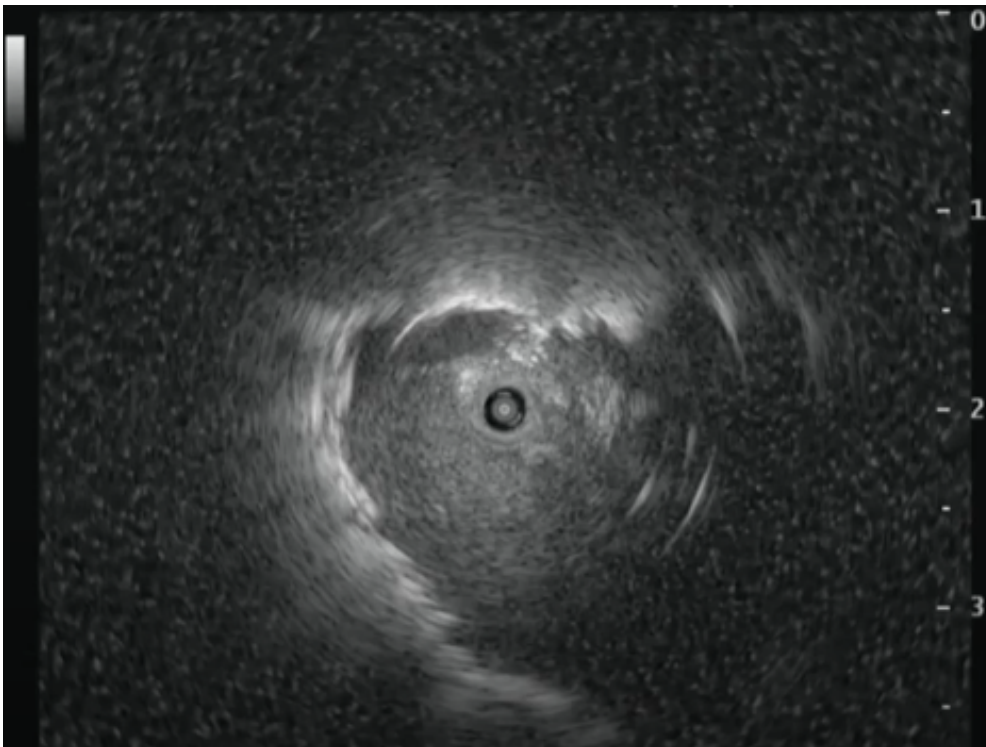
Radial probe endobronchial ultrasound
